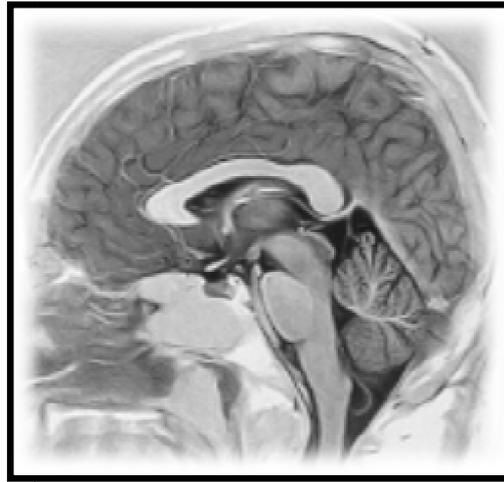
High resolution sagittal MRI brain image (Philips). [15]
